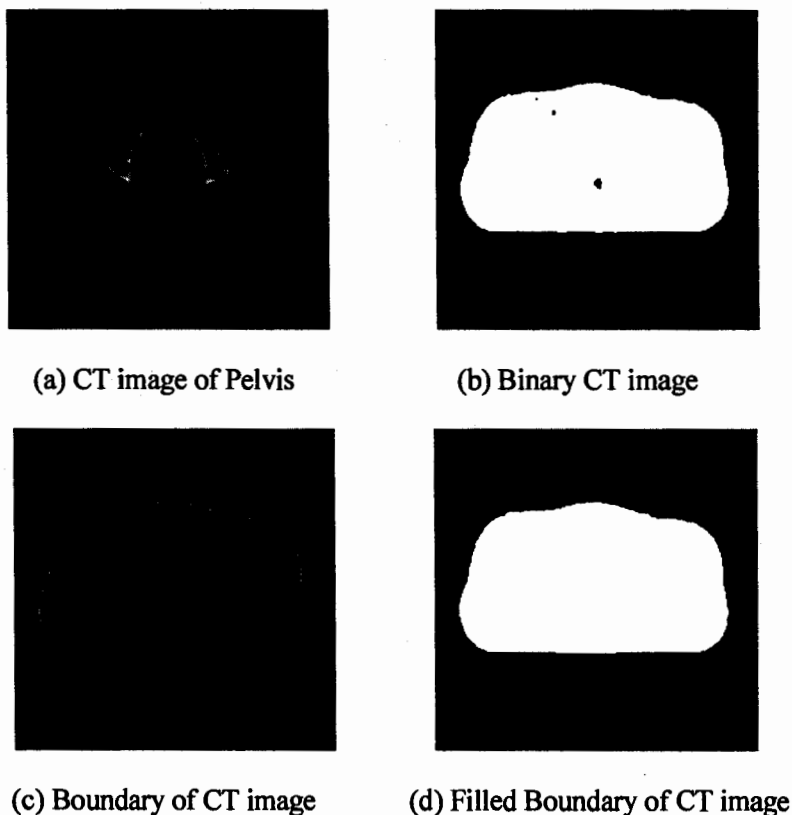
Steps to make foreground as a single region in CT image of Pelvis
